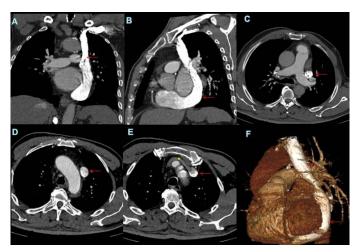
Contrast enhanced CT with Coronal (A), sagittal (B), axial slices (C, D, E) and 3D reconstruction (F) showing the absence of the right superior vena cava and persistent isolated left sided superior vena cava (red arrow) lateral to the aortic arch, draining via the coronary sinus into the right atrium which is dilated
